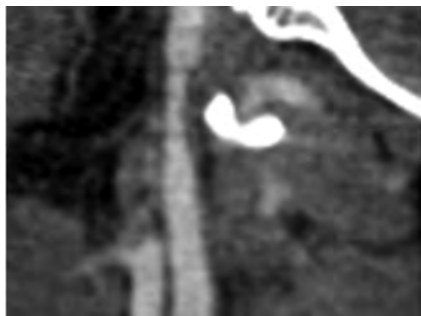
Internal carotid artery injury in patient 3. Sagittal reformat of a neck CTA image showing >25% ICA narrowing related to grade II injury in a 9.92-year-old girl, status post MVC with ejection, who was found unconscious in the field with fixed and dilated pupils.
